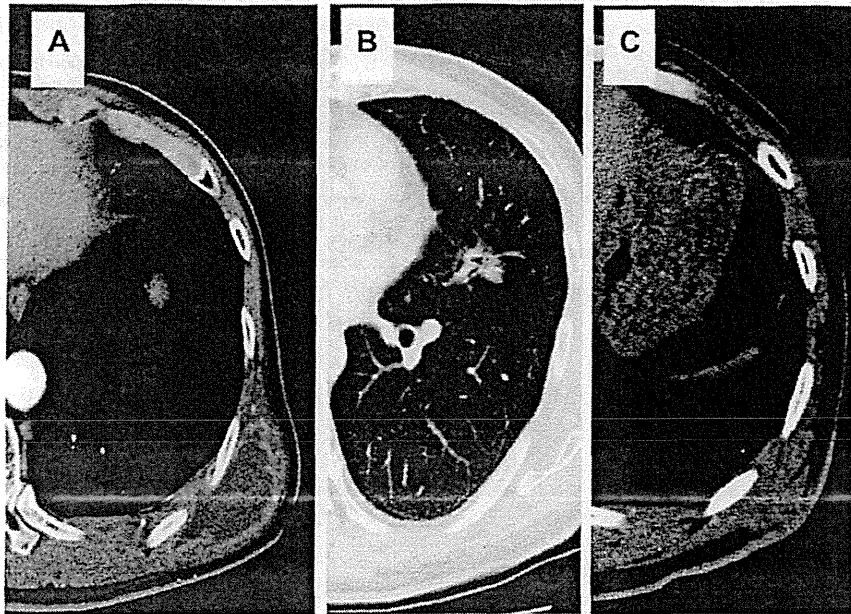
A. Enhanced chest computed tomography (CT) showing a peripherally enhancing fluid collection in the chest wall adjacent to the seventh and eighth ribs. B. A mixed ground glass opacity was detected in segment 4 of the left lung. C. Chest CT 3 months after the surgery showing minimal inflammatory change.
